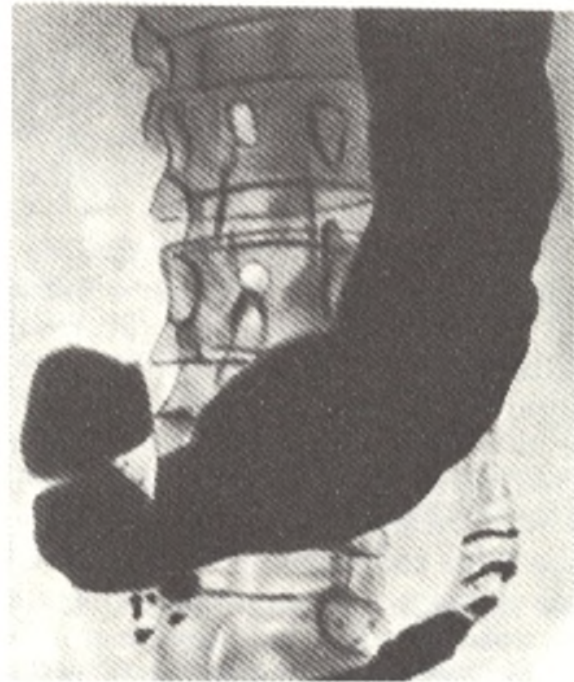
Stomach shaped like an elongated hook (radiograph)
